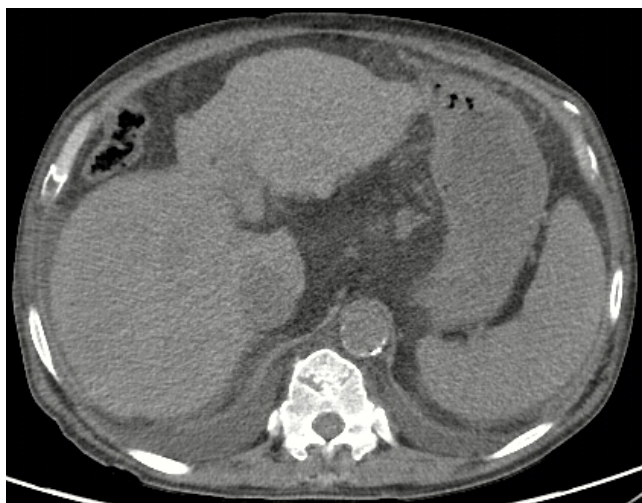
Plain computed tomography scans in the second patient
